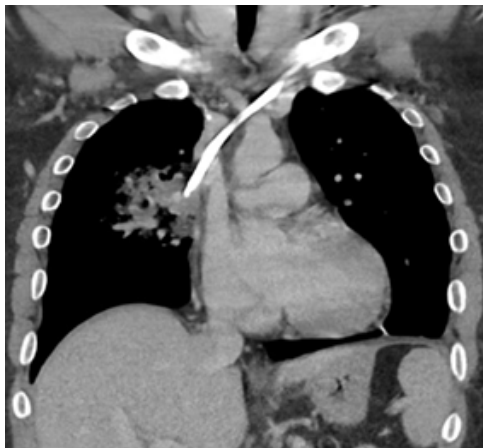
Coronal computed tomography scan of the chest in the venous phase with better delineation of the vascular structures, which shows protrusion of the line through the superior vena cava.
